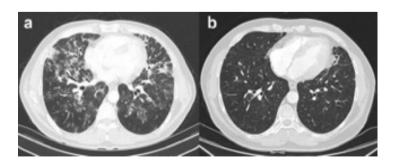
Thorax computed tomography. a) Peribronchovascular fibrotic changes consistent with organizing pneumonia in both lungs, traction bronchiectasis and ground-glass opacities in the form of confluent in places. b) Significant regression in symptoms after one year of corticosteroid therapy.
